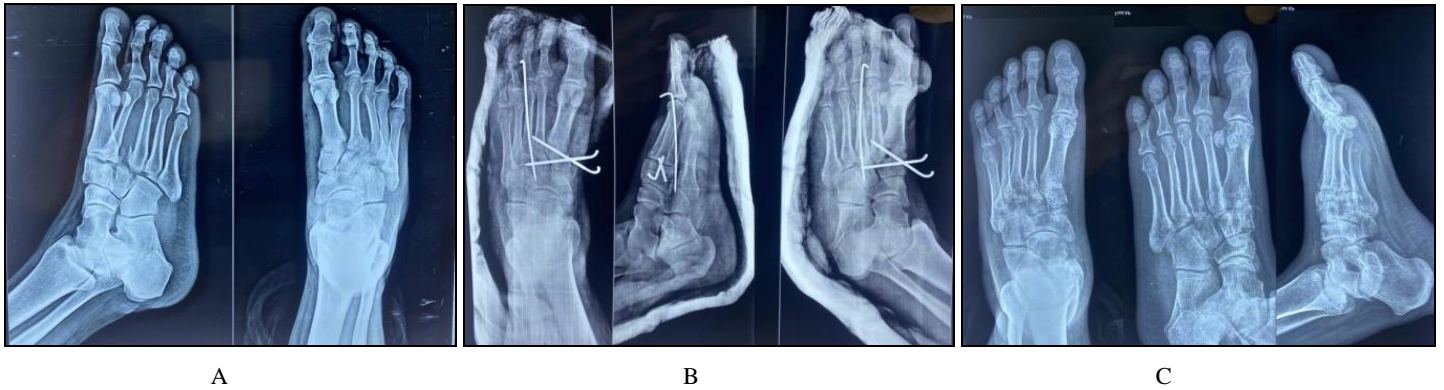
A (pre-operative radiograph), B (Immediate post-operative) and C (Final follow-up at 6 months)
